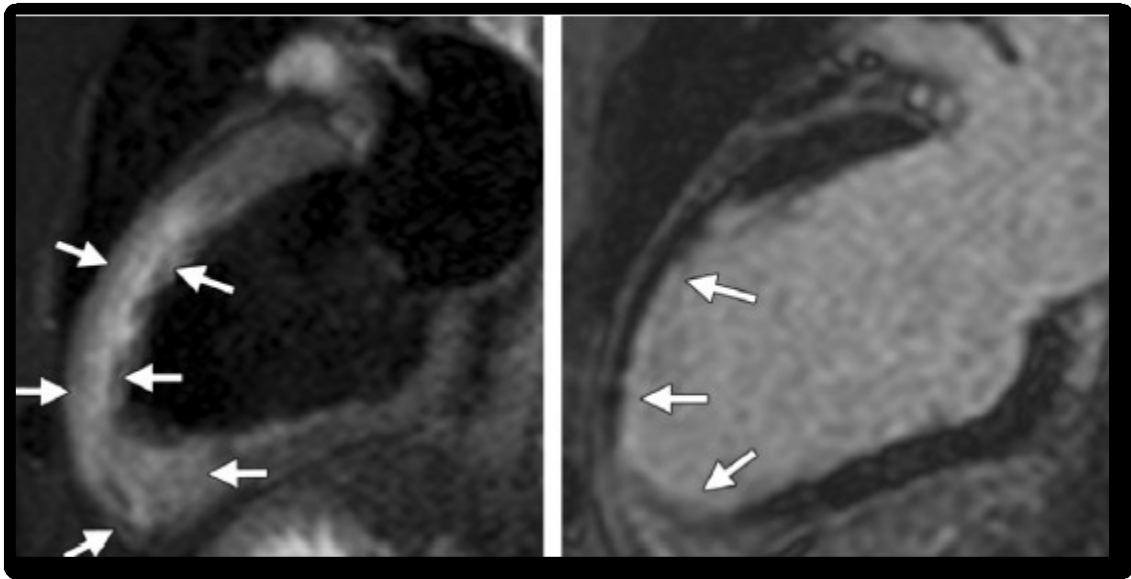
MR imaging findings in acute MI. Two-chamber T2-weighted STIR image shows high-signal-intensity myocardial edema in the mid and apical anterior wall (Left). Two-chamber delayed-enhancement image shows subendocardial scarring in the mid to apical anterior wall (Right)
